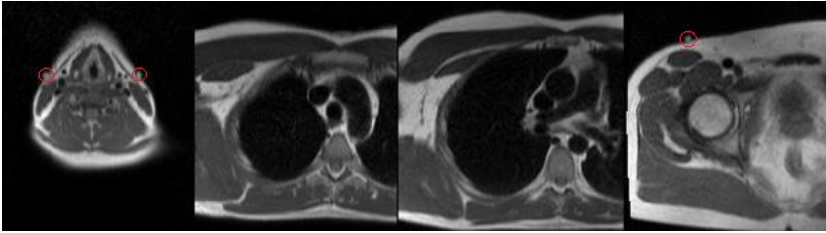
Four examples of cross-sectional MRI images used to trace the reference distance: from left to right: carotid artery, truncus brachiocephalicus, aortic bifurcation, femoral artery. The position of the vitamin A pearls (body surface measurement points) is indicated by red circles.
